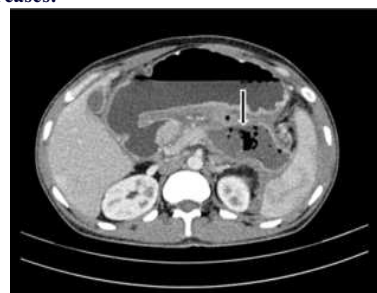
Axial image of contrast enhanced CT examination shows infected pseudocyst (arrow) as one of the commonest local complication of acute pancreatitis.
